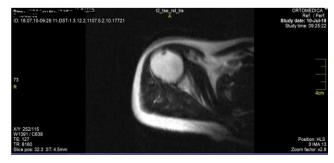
MRI scan done after the treatment
